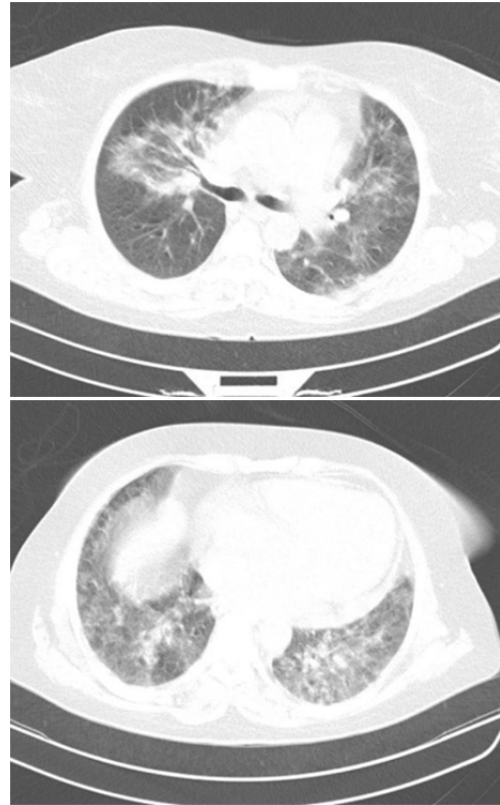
Patient's CT-scan at her first admission. Severe lung involvement is seen in both lungs.
